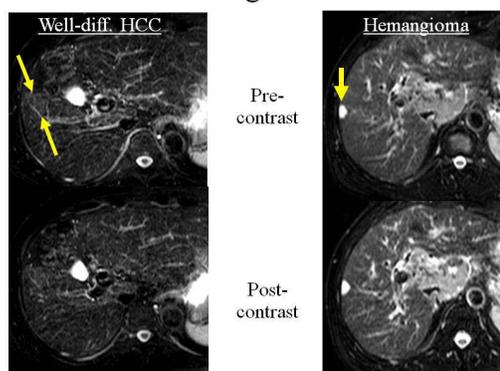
Effect of EOB on DWI
